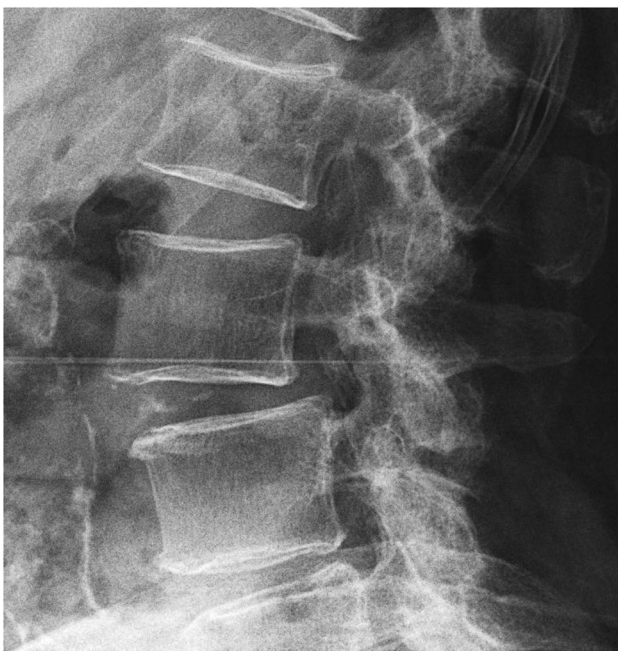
Conventional radiography of the lumbar spine – lateral view at the level of L2-L4
